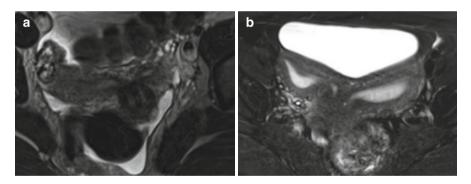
(a) is an axial T2-weighted image showing a typical uterus didelphys, two widely splayed uterine horns with bilateral, non-fused, fully developed cervices, which is critical for distinction from bicornuate uterus. (b) is a uterus didelphys which has two relatively separate cavities
